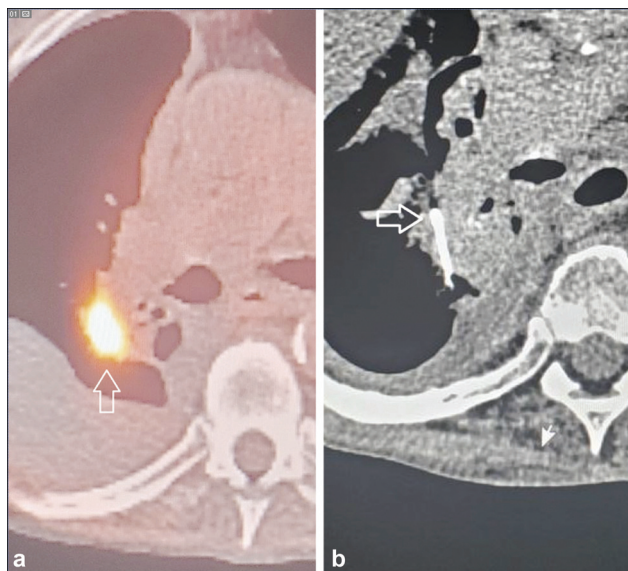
Patient with a right perihilar mass which was PET-CT avid (a, arrow). Bronchoscopic fine needle aspiration biopsy was nondiagnostic. Core biopsy samples were obtained under CT guidance (b; arrow—needle tip). Pathology was consistent with squamous cell carcinoma.
